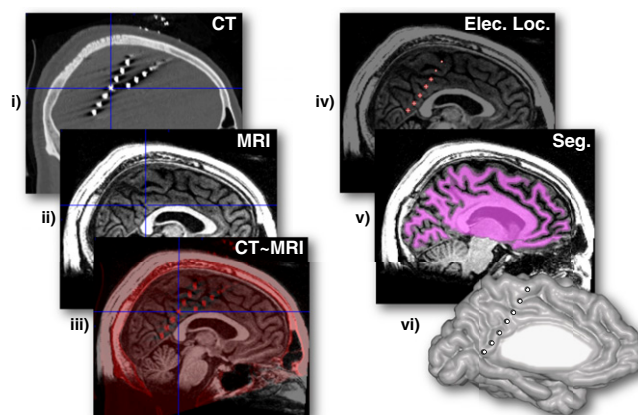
Localization of electrodes using CT-MRI fusion. The location of recording electrodes on the cortical surface was determined by registering the postimplant CT image with a high-resolution preoperative T1 anatomical MRI scan (*i–iii*). After this alignment, electrode coordinates for each strip or grid electrode array were localized separately within the individual subjects MRI head space (*iv*). These coordinates were then located upon the cortical surface extracted from a manual segmentation of the MRI white matter with a cortical layer expansion (*v* and *vi*).
